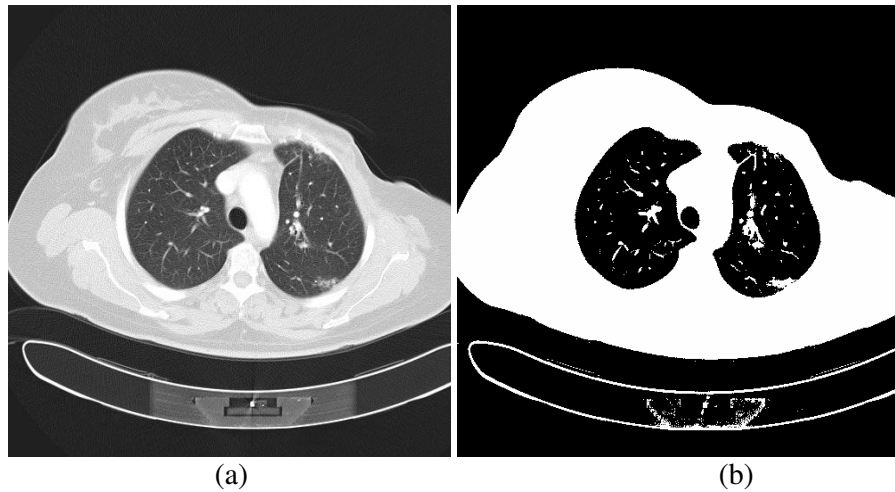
3: Result of thresholding for the CT image, (a) Original image, (b) Result of thresholding, (c) histogram of the original image.
